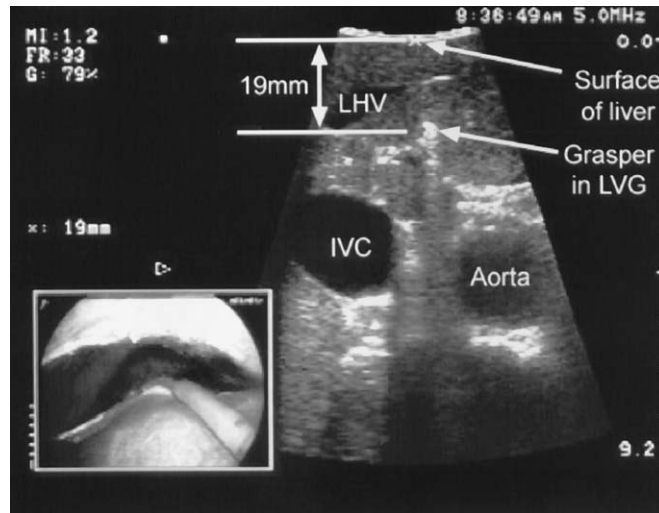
Laparoscopic ultrasound view. The hepatic parenchymal thickness is measured at the ligamentum venosum groove, and its relationship to the left hepatic vein is assessed. LHV = left hepatic vein; LVG = ligamentum venosum groove; IVC = inferior vena cava.
